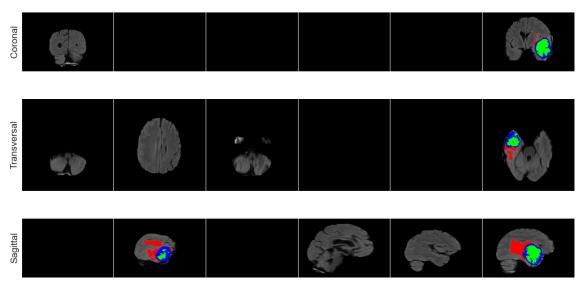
Annotated Brain Magnetic Resonance Imaging Scan, BRATS 2021
